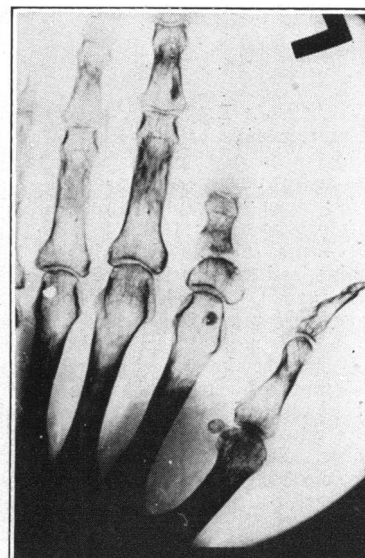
Case 2; x-ray two years after lesion.
